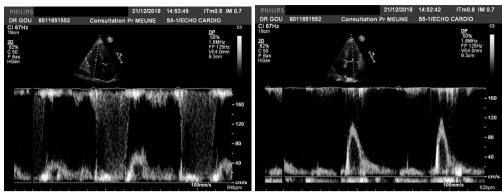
Pulsed doppler analysis tricuspid and mitral patterns.
